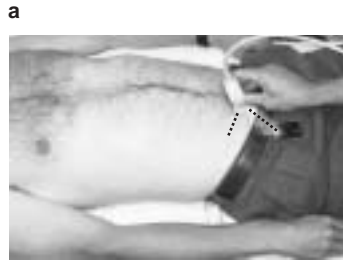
a,b,c. Normal and abnormal negative sonographic examinations for the cardiac window.
